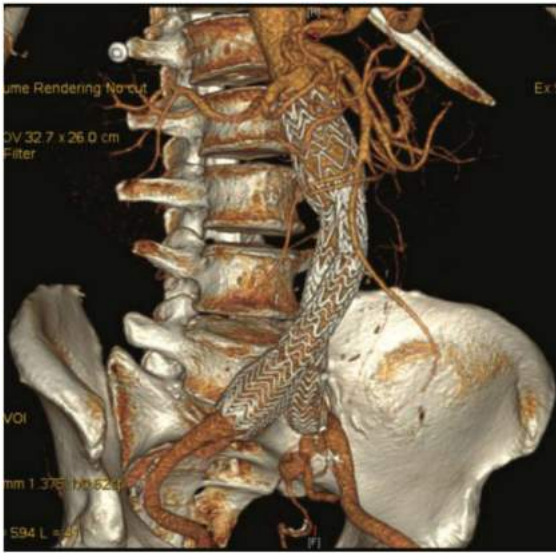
• Postoperative imaging. 3-D reconstruction of a CT aortogram in a patient who have undergone successful EVAR at 1 month follow-up.
